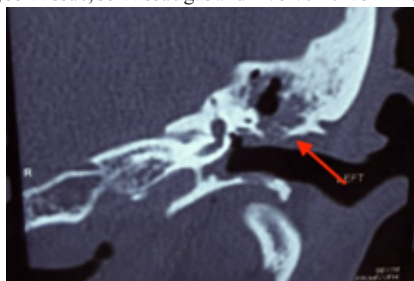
CT Scan showing erosion with fluid / soft tissue of bone on
